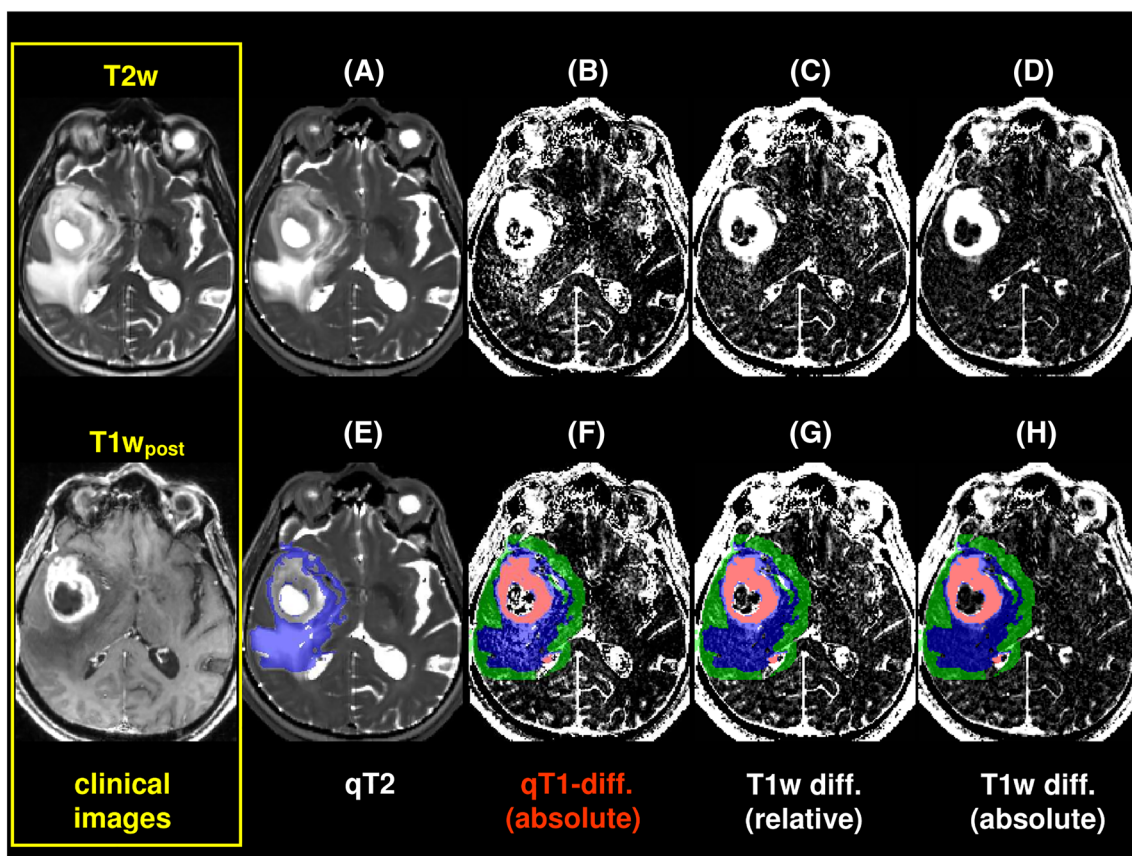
Data of a patient with a left-temporal glioblastoma with central necrosis surrounded by peritumoral edema. The yellow frame (left) shows a conventional T2-weighted (T2w) image (top) and the T1w image post contrast agent (T1w_{post}) (bottom) for orientation. Further, the top and bottom rows show from left to right: quantitative T2 (qT2) map (A, E), absolute qT1-difference map (B, F) and relative (C, G) and absolute (D, H) differences of T1w images. In the bottom row, the volume of interest (VOI) masks are superimposed: enhancing tumor (red), edema (blue) and 5 mm zone (green). In contrast to the absolute difference of the T1w images (D, H), the qT1-difference map (B, F) shows elevated values in the edema region (blue mask) as well as in the necrotic center, which is hardly visible in the relative difference of the T1w images (C, G) due to elevated noise
